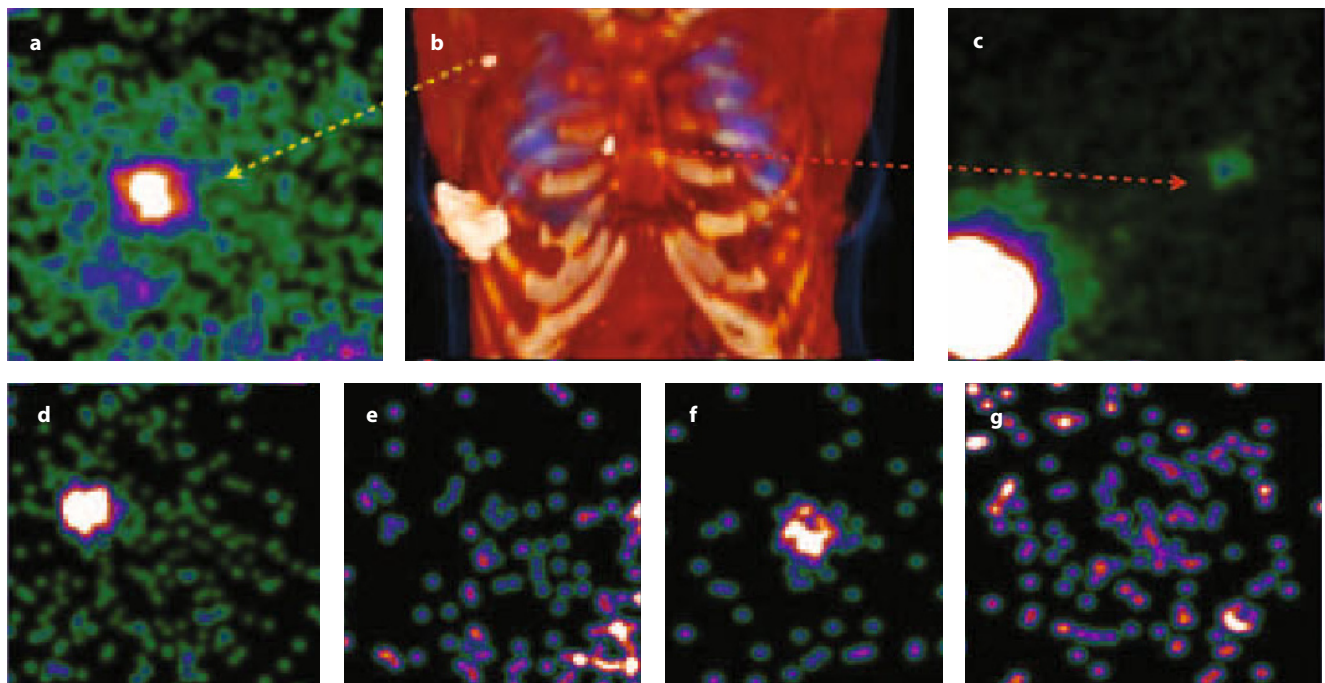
Utility of the portable gamma camera during surgery for the certainty of SLN resection. a Radiotracer uptake displayed on gamma camera, corresponding to the node depicted in the axillary area (*yellow arrow*) on the 3D volume rendering reconstruction of a breast cancer patient with lymphatic drainage to the axilla and inner mammary chain (b). c A parasternal sentinel node (*red arrow*) is also depicted with the gamma camera. d Preoperative image of the axilla showing a highly active sentinel node. e Image after axillary node retrieval informs about the absence of other significant tracer uptake. f, g A similar approach in the internal mammary chain sentinel node
